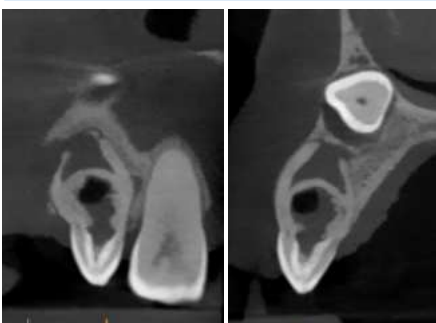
Sagittal slice of CBCT radiograph depicting a periapical radiolucency causing dehiscence of the buccal cortex.
